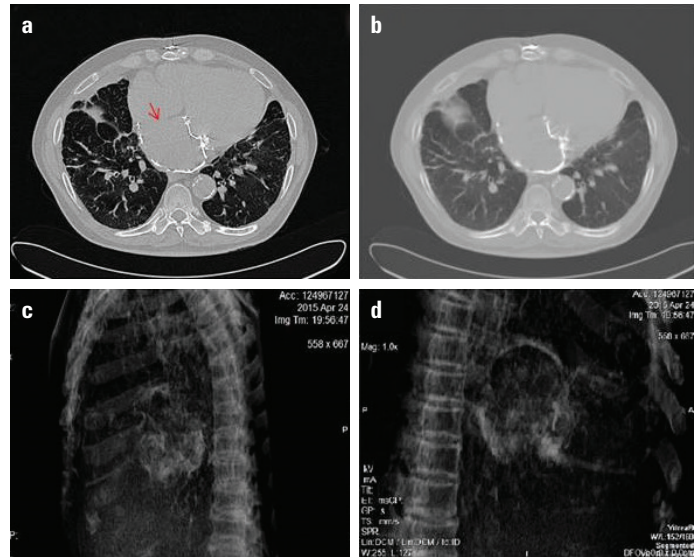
Multislice contrast-enhanced computed tomography (CT) of the thorax. Axial (a and b) and sagittal (c and d) images showing extensive and diffuse calcification outlining the LA free wall, except in the interatrial septum (red arrow)
